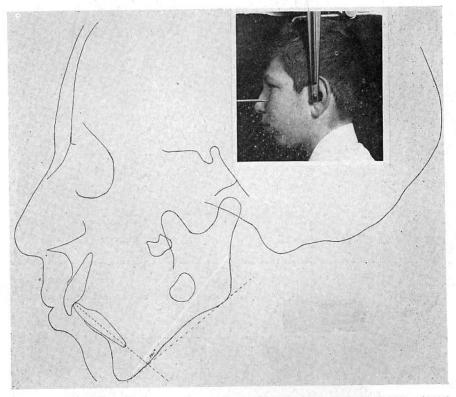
A tracing of a sagittal cephalic x-ray of a boy aged 11 years. Arrest in growth of rami and inferior border of mandible. Not a true bimaxillary protrusion. Prognosis not good for obtaining nonprognathous profile.
